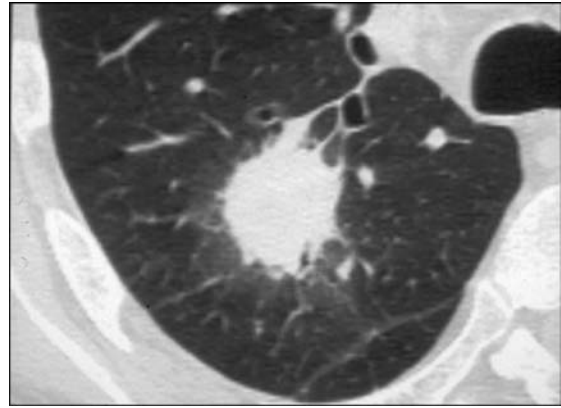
Kidney transplant recipient with cough and fever. Pulmonary nodule seen on chest CT scan read as “Likely *Aspergillus*” by radiologist. Biopsy demonstrated *Nocardia asteroides*.
